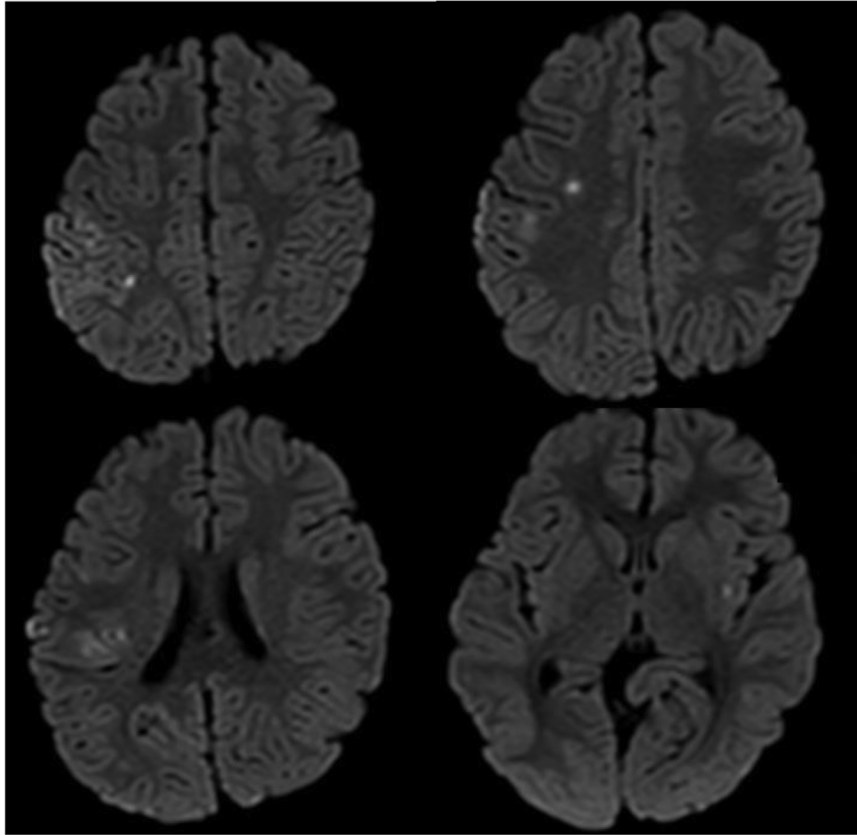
Magnetic resonance image showing multiple strokes (high signal) on diffusion-weighted imaging.
